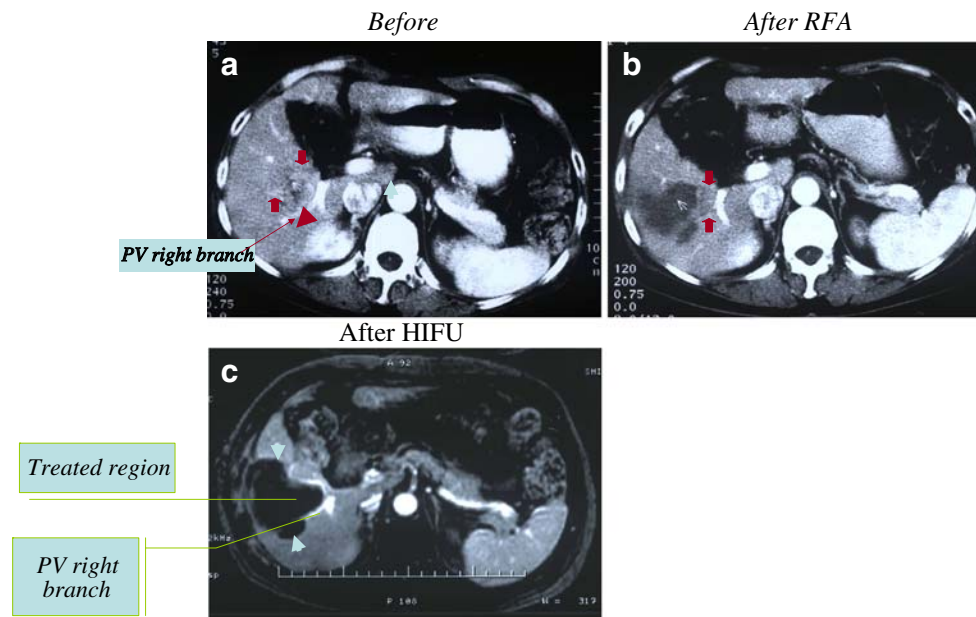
Transverse contrast agent-enhanced CT and MRI of a patient (case 3) with HCC treated sequentially with RFA and then HIFU. The patient is a 64-year-old woman with HCC treated by HIFU after RFA. a Pre-treatment. CT obtained in the hepatic arterial phase shows a large hypervascular tumor (bold arrows) located close to right branch of portal vein in Couinaud segment 5. b Post RFA treatment. Contrast-enhanced CT obtained in the hepatic arterial
